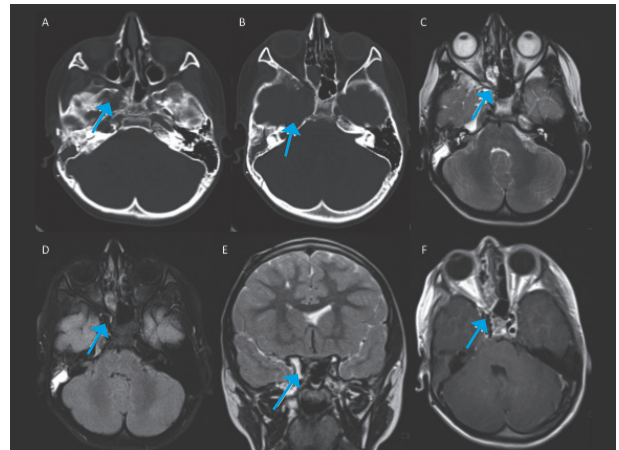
Computed tomography (A, B) and magnetic resonance imaging (C-F) scans. Destruction of bone trabeculae in the right mastoid, in a probable relationship with a local inflammatory/osteolytic process, destruction of the right greater sphenoid wing (A, arrow) and right petrous apex (B, arrow). Axial T2 (C) and fluid attenuated inversion recovery (FLAIR) (D) revealing the extension of the osteoclastic process to the right cavernous sinus, whose anatomy is altered (coronal T2) (E), having ceased to be a venous structure (axial T1 after gadolinium administration) (F). The arrows (C-F) point to the right cavernous sinus, the differences observed in comparison with the contralateral structure being particularly evident. There is no engorgement of the structures that drain the right cavernous sinus, namely the ophthalmic veins and the spheno-parietal sinus is only slightly enlarged. Being a slow process, compensation mechanisms have naturally been developed, which can pass through the left cavernous sinus, since they communicate with each other. Although not visible in the image, the right internal carotid artery is patent and has a normal path.
